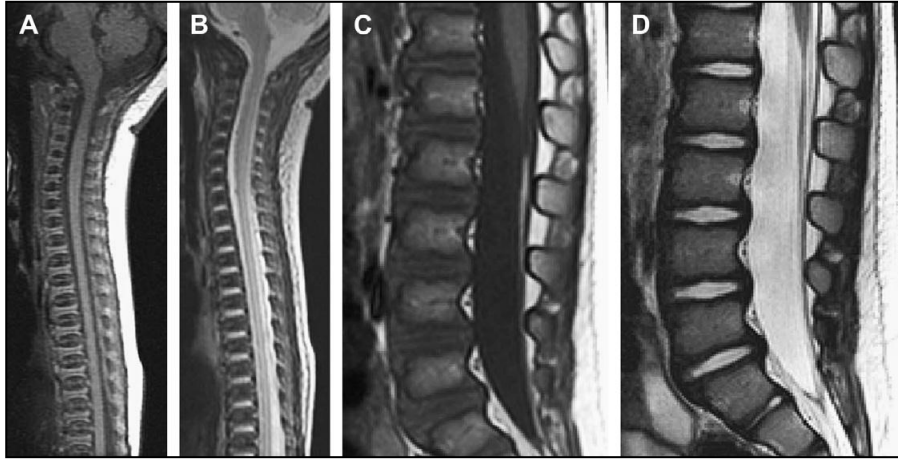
Normal marrow conversion in the spine. Normal appearance of the upper spine in a 1-day-old baby. Note the appearance on T1-weighted (a) and T2-weighted sequence (b). Contrast this with the appearance in the lower spine in a 17 month old where there is increased fat present in the vertebrae especially adjacent to the basivertebral vessels on T1-weighted (c) and T2-weighted sequences (d) (*Quoted from Hwang and Panicek, 2007*).
